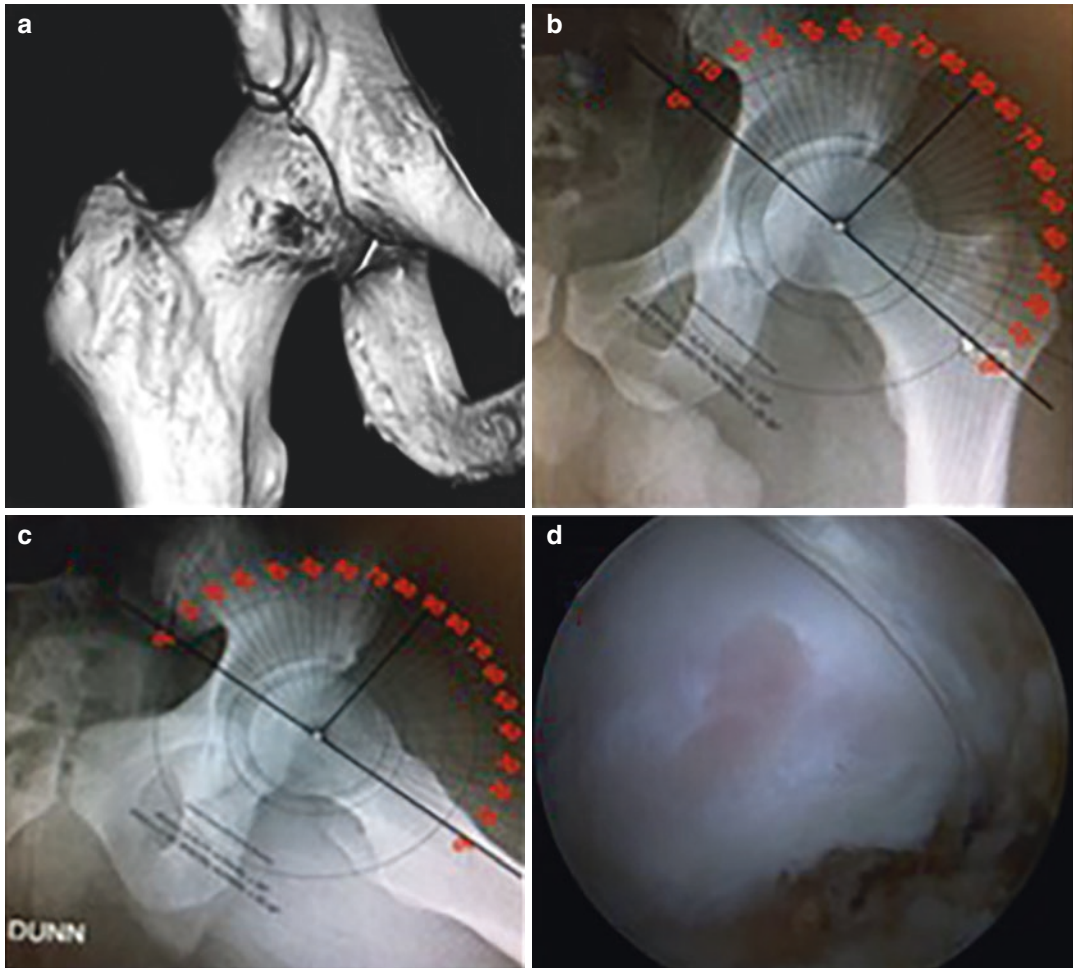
Cam-type impingement. (a) Cam deformity as seen on CT scan; note prominence of anterior femoral neck (*arrow*); (b and c) cam deformity best evidenced on
